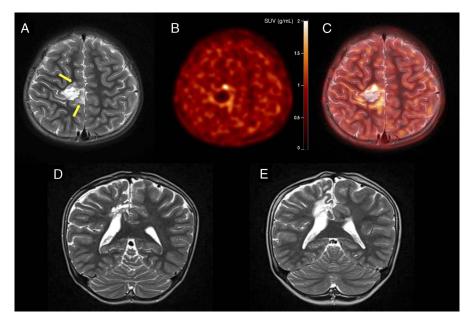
A case with a residual tumor exhibiting high uptake on follow-up MET-PET and event occurrence after reoperation. MRI scans of a 4-year-old boy who underwent tumorectomy for a DNET involving the adjacent cortex in the right central lobe and the posterior cingulum. The tumor was subtotally resected, and seizures recurred at 1.0 years postoperatively. On follow-up MRI and MET-PET images (A–C), the residual tumor was confirmed to have increased MET uptake at the margin of the tumorectomy site (arrows). The patient underwent reoperation, and NTR of the tumor was observed on postoperative MRI (D). Tumor progression was confirmed on 4.3 years follow-up MRI (E), and the patient is still on clinical surveillance because of the absence of symptoms.
